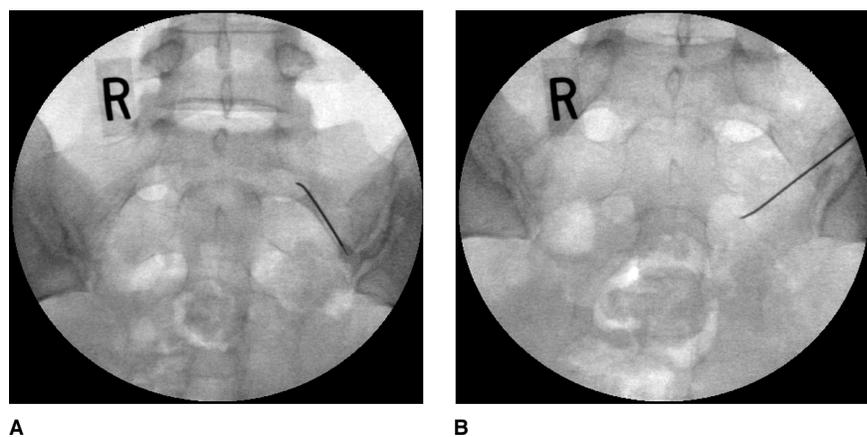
Anteroposterior radiographs of a sacroiliac joint radiofrequency neurotomy procedure. A, One of the lateral branches of the S1 dorsal ramus. B, One of the lateral branches of the S2 dorsal ramus.
